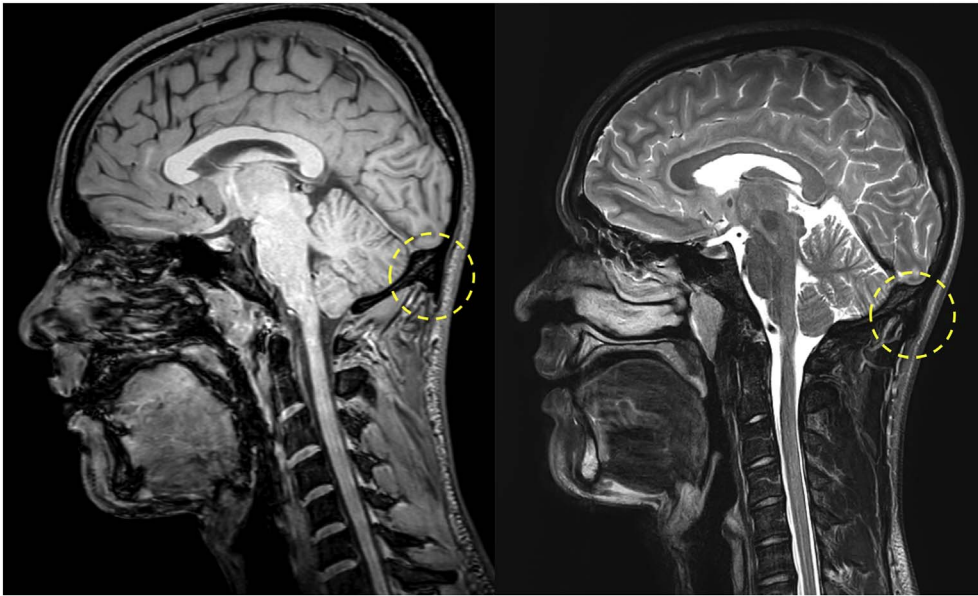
Images representing MRI scans of a 16-year old male participant, showing a T1 weighted mid-sagittal image (left) demonstrating the enlarged external occipital protuberance (EOP). This image separates bone from soft tissues. The right image shows T2 weighted mid-sagittal image, with these T2 fat suppressed images highly sensitive for the detection of edema. The lack of signal demonstrates no inflammation at the EOP and surrounding structures. The linear high signal structures adjacent to the EOP are normal blood vessels.
